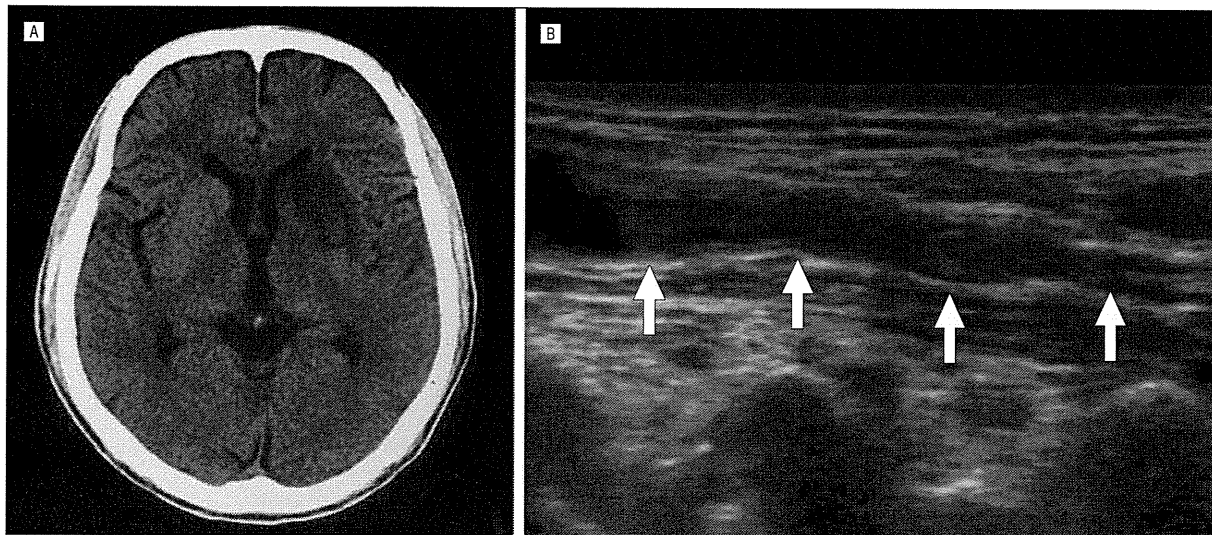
Imaging findings on admission. A, Brain computed tomography shows an ischemic lesion in the left basal ganglia. B, Carotid ultrasound shows a thrombuslike entity in left internal carotid artery.
